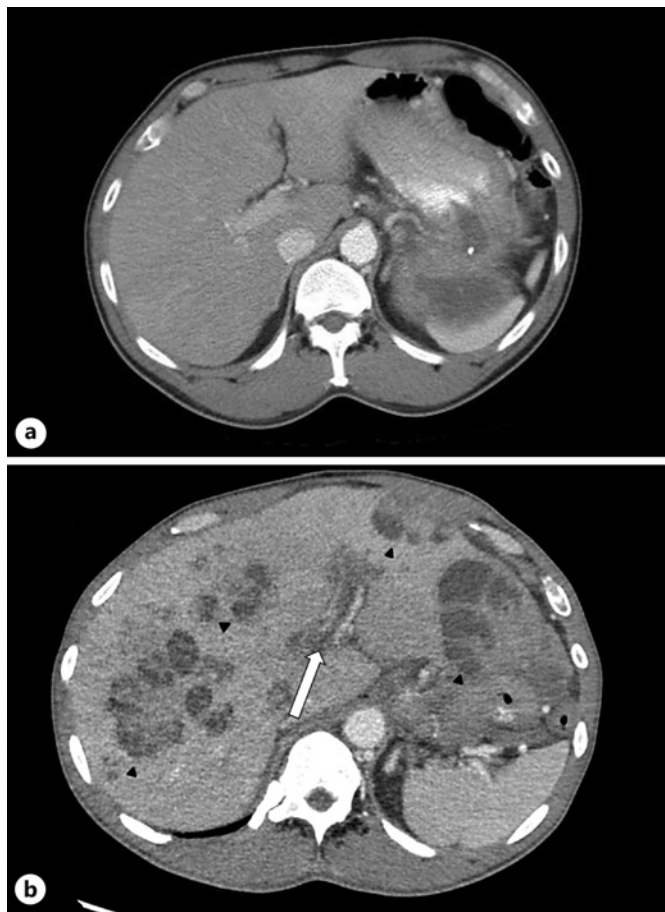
a Transverse CT image of the abdomen taken 6 months prior to presentation. b Transverse CT image of the abdomen demonstrating multiple lesions throughout the grossly enlarged liver indicated by black arrows and hypoattenuation indicating thrombosis within the portal vein showcased by white arrow.
